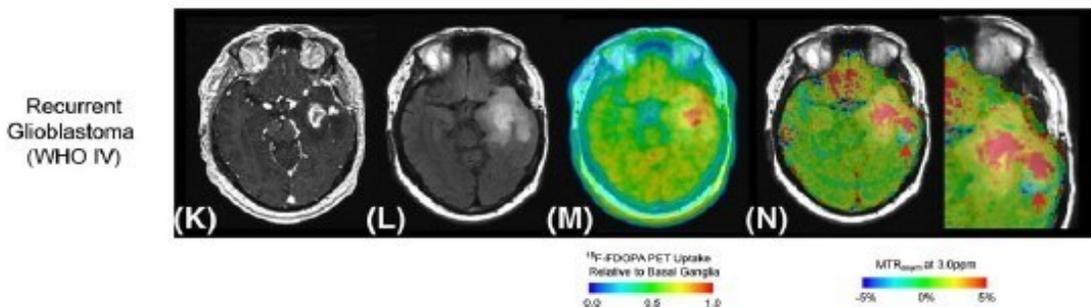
Hypoxia Weighted CEST-EPI-MTR Imaging showing (K) post-contrast T1-weighted image of a centrally ringenhancing recurrent GBM, (L) fluid attenuated inversion recovery (FLAIR) image of this lesion with surrounding edema, (M) FDOPA-PET demonstrating central regions of increase dopamine uptake, and (N) hypoxia-weighted CEST-EPI-MTR sequences showing regions of hypoxia extending beyond the centrally enhancing necrotic focus into region of FLAIR abnormality.
